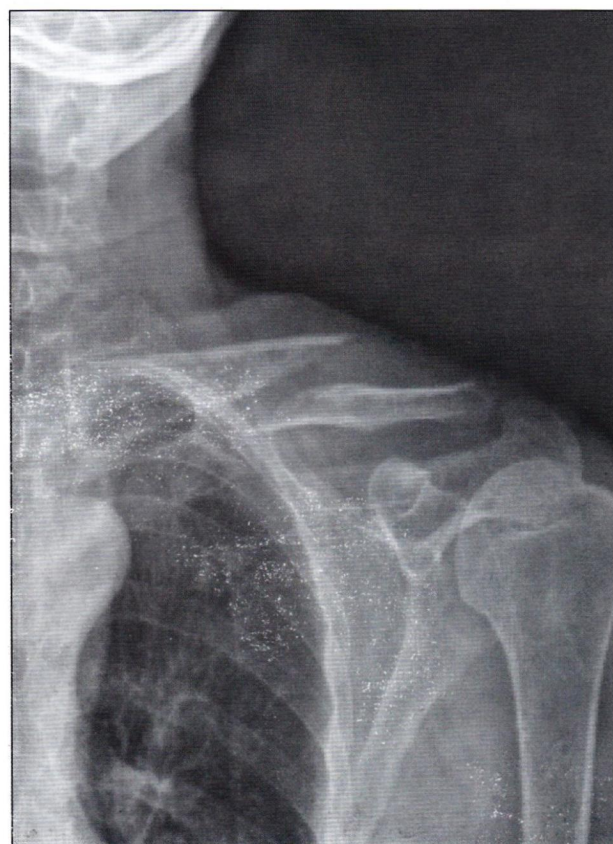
Pre-operative X-ray
